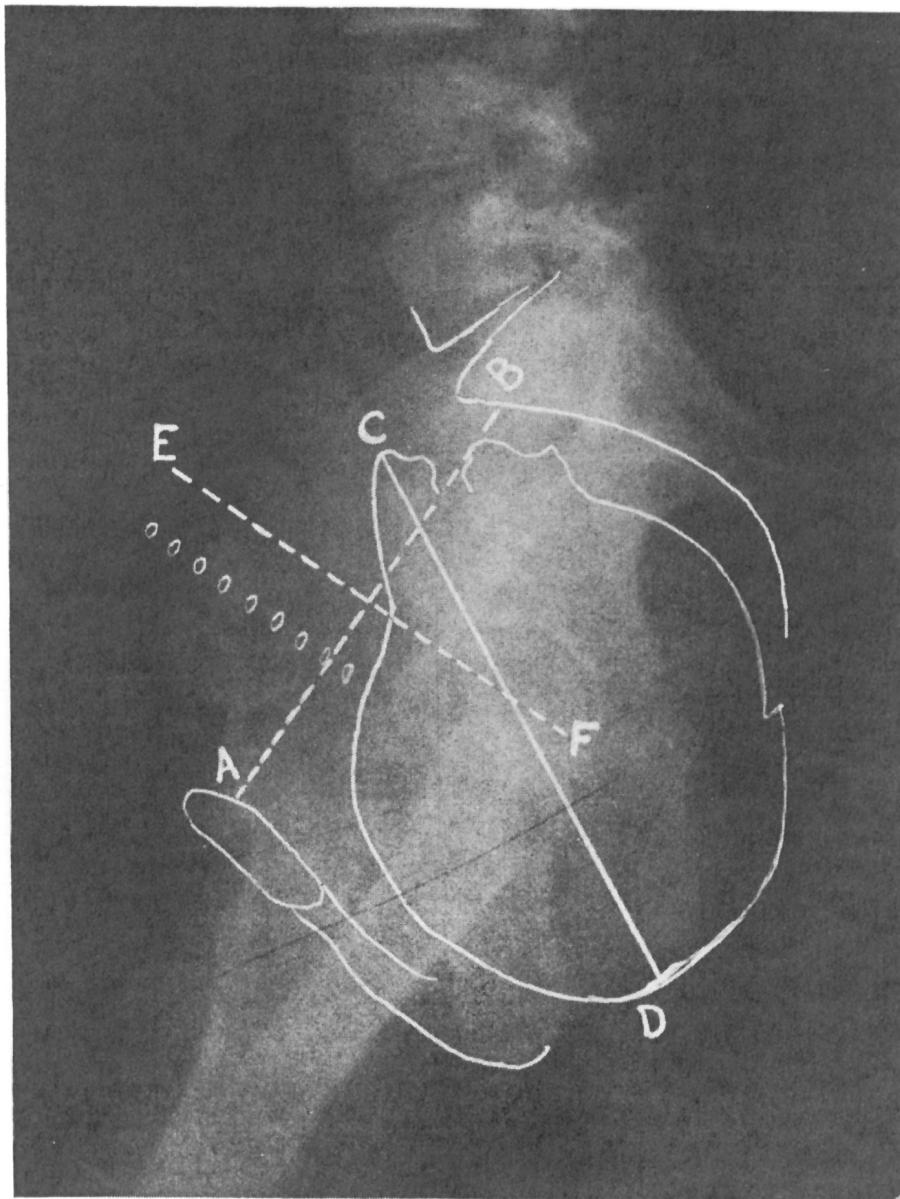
Lateral roentgenogram late in labor. *A. B.*, First plane of inlet and true conjugate diameter. *C. D.*, Long axis of fetal head. *E. F.*, Perpendicular to inlet through midpoint of true conjugate diameter. Head in fore pelvis with back anterior and parallel to symphysis. Long axis of head *C. D.* points into upper posterior pelvis. Fetal back in advance of *E. F.* in axis of fore pelvis (see *G. F.*, Fig. 24).
